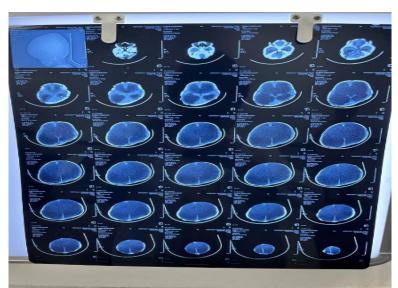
Congenital Hydrocephalus due to Aqueductal Stenosis (CT Image)
